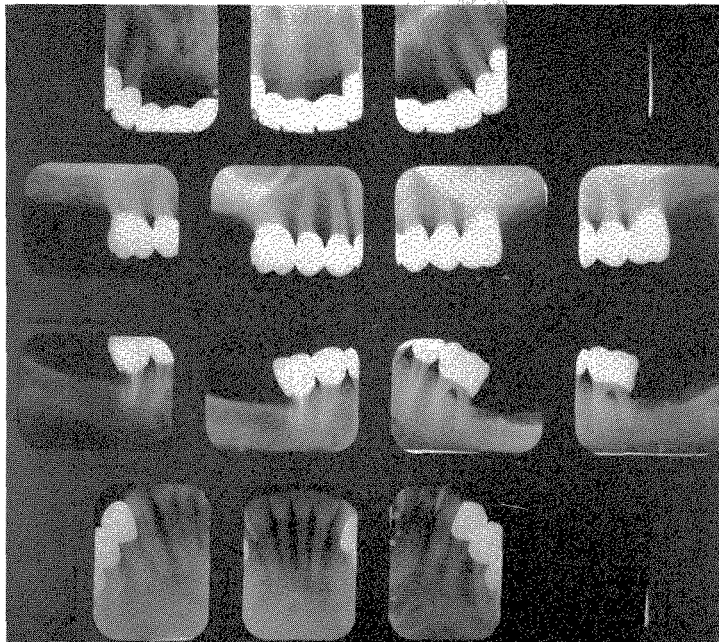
Roentgenograms taken in March, 1962.
